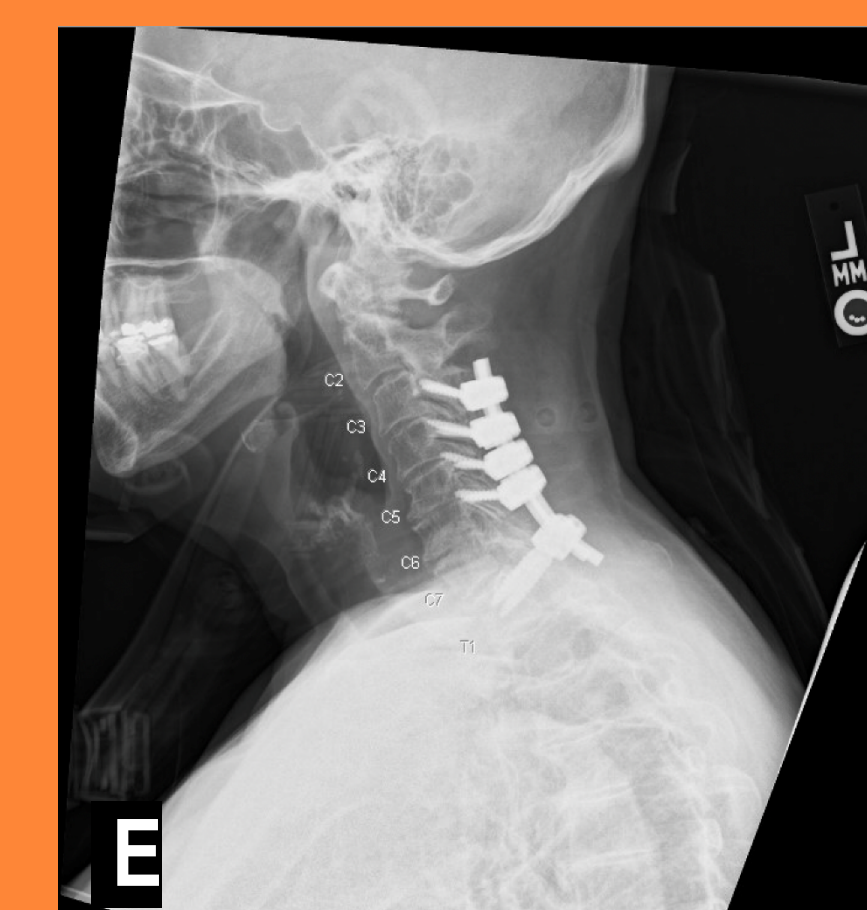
Cervical spine imaging including (A) sagittal T2 MRI and (B) coronal T2 MRI demonstrating myelopathy and myelomalacia (C) extension Xray with 2mm C5/C6 mobility, and (D) CT scan with osseous spinal stenosis with C5/C6 retrolisthesis.
